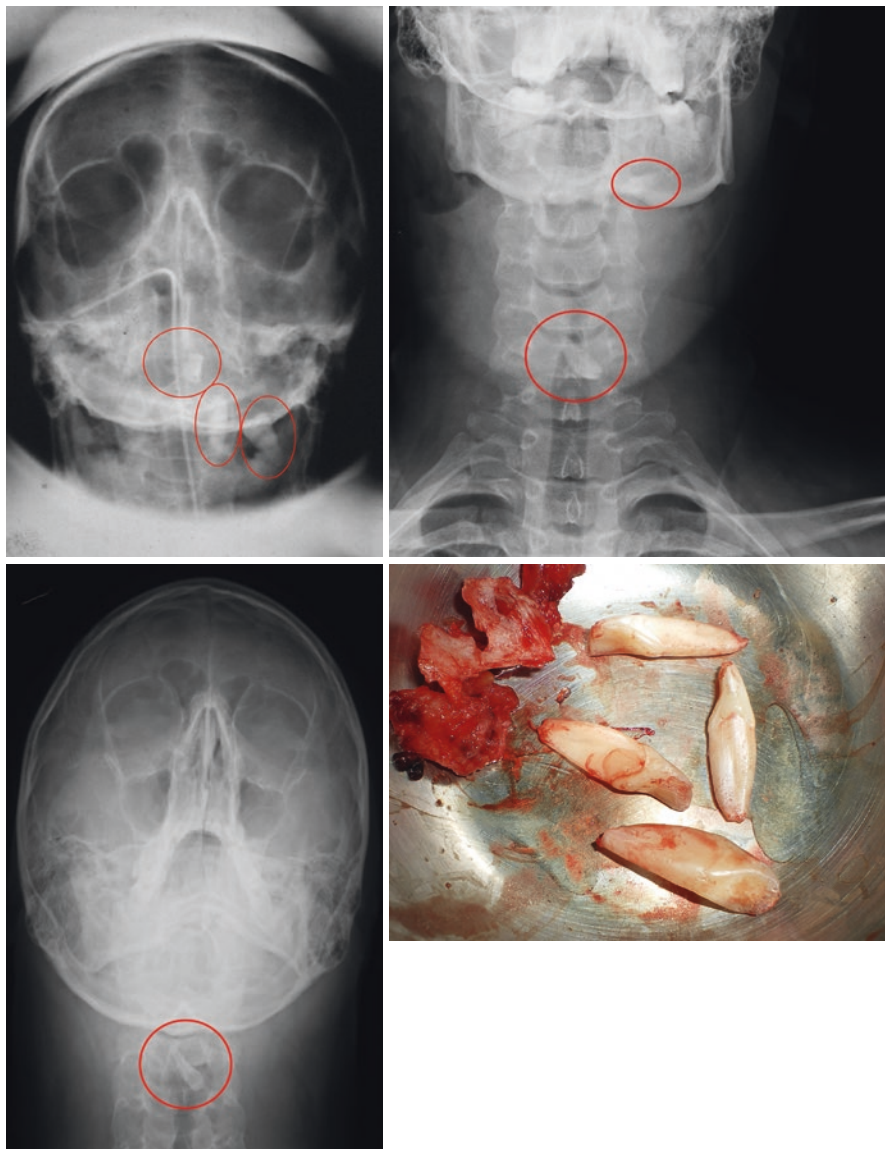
Further examples of teeth in the upper airway. A chest radiograph alone is inadequate
